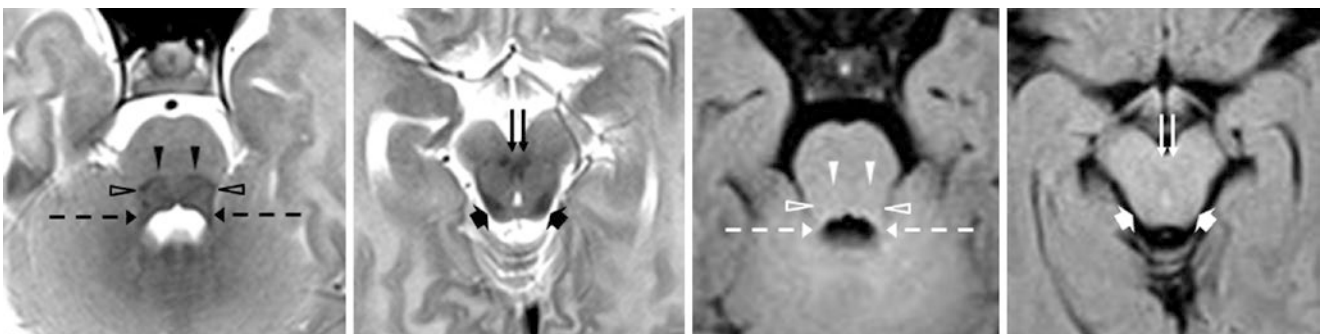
A 1-day-old term neonate had a normal 3T MRI with axial SE T2WIs (left images) and 2D FLAIR (right images). There is T2-dark myelination of the BIC (wide arrows), DSCP (double arrows), LL
